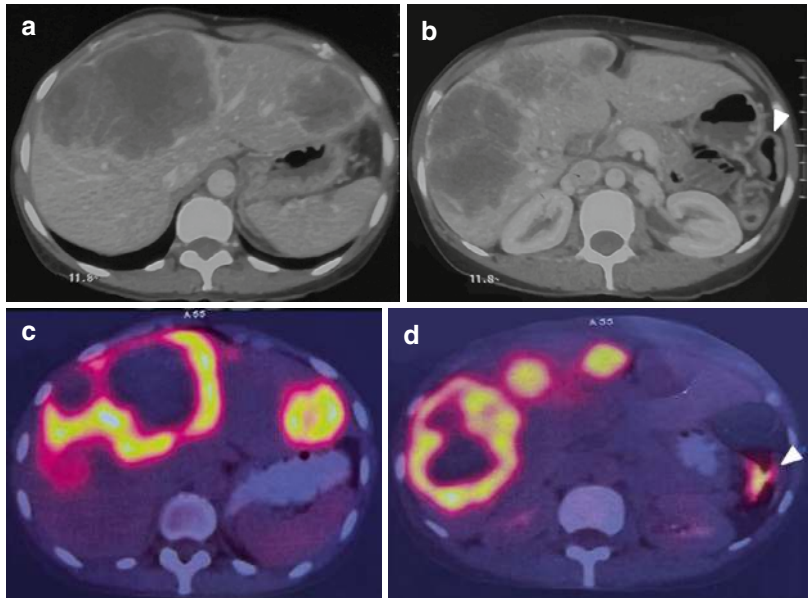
A 55-year-old female with hypovascular metastasis from colon cancer. (a, b) Axial contrast-enhanced CT images (venous phase) showed multiple, irregular peripherally enhancing lesions in the liver. (c, d) Axial ^{18}F FDG PET-CT images show avid uptake in the liver lesions. The primary malignancy is seen in the splenic flexure as circumferential wall thickening (arrowhead in b) with avid FDG uptake (arrowhead in d)
